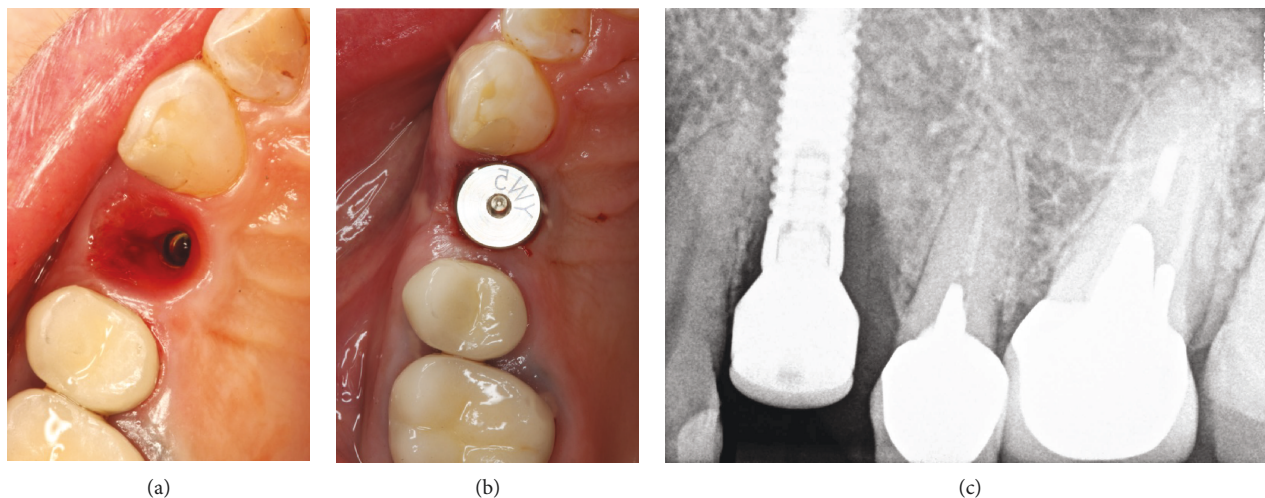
(a) Peri-implant sulcus after removal of cement excess, (b) healing abutment connection, and (c) radiographic verification.
